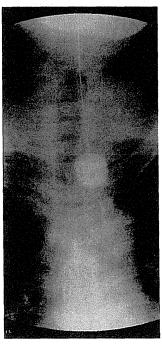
Radiograph of RFB placed at cervical esophagus.
